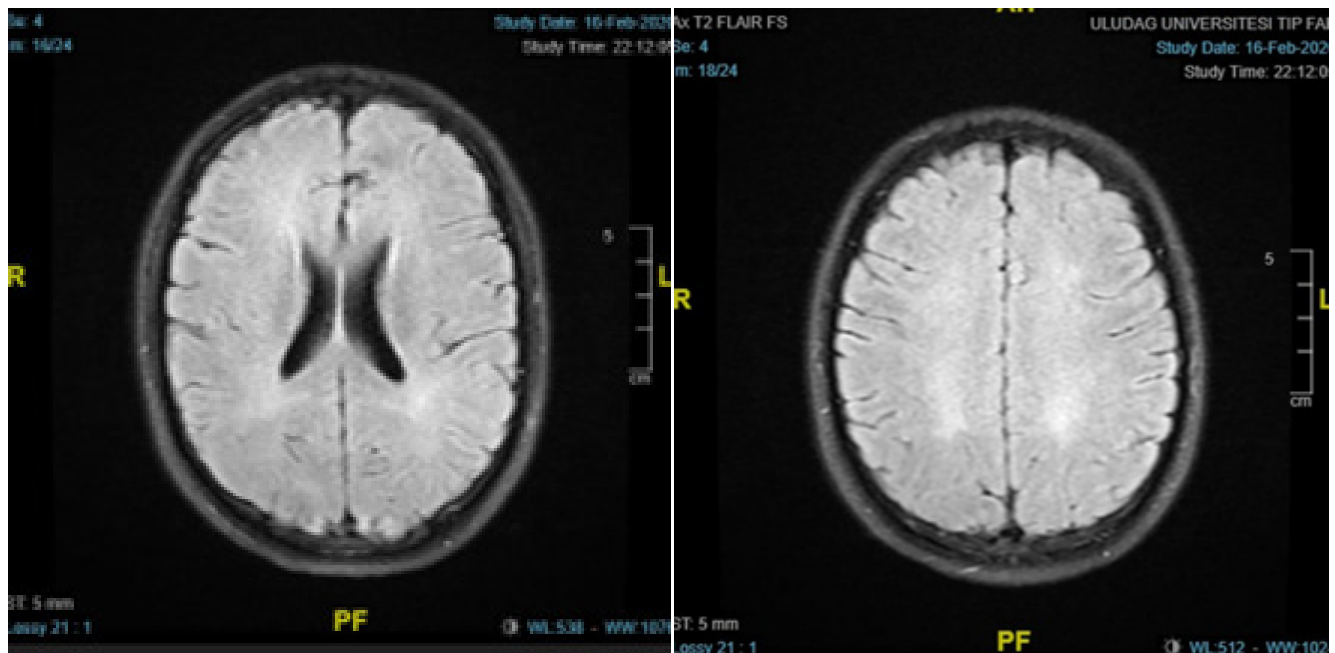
Cranial MRI imaging: T2 Flair images: Marked dysmyelination of the white matter in deep periventricular and supraventricular areas.
